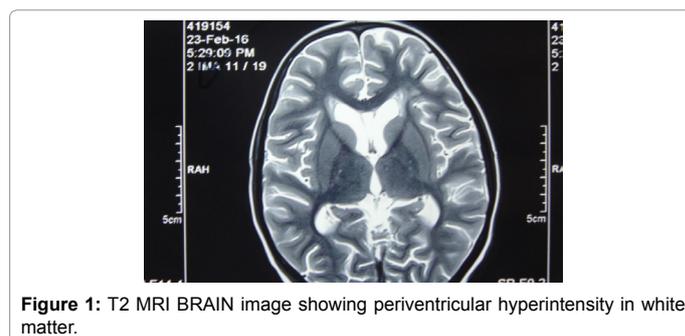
T2 MRI BRAIN image showing periventricular hyperintensity in white matter.
